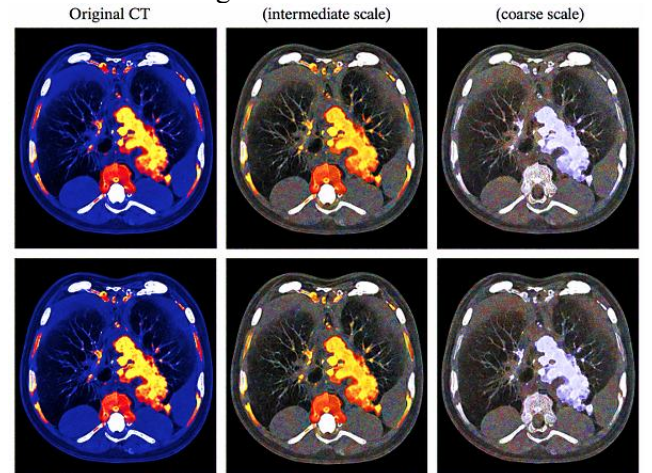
Multichannel diffusion of lung CT pseudo-color image using Beltrami flow at increasing scales.
